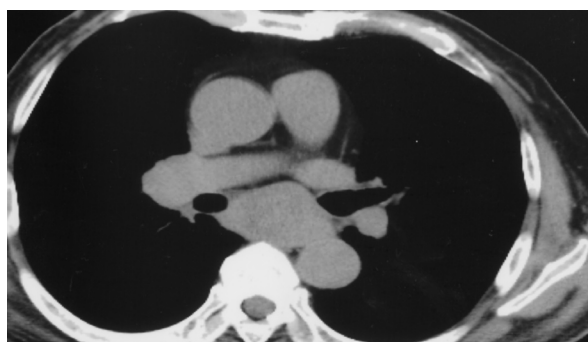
Computed tomography of the chest showing the subcarinal soft tissue mass lesion
